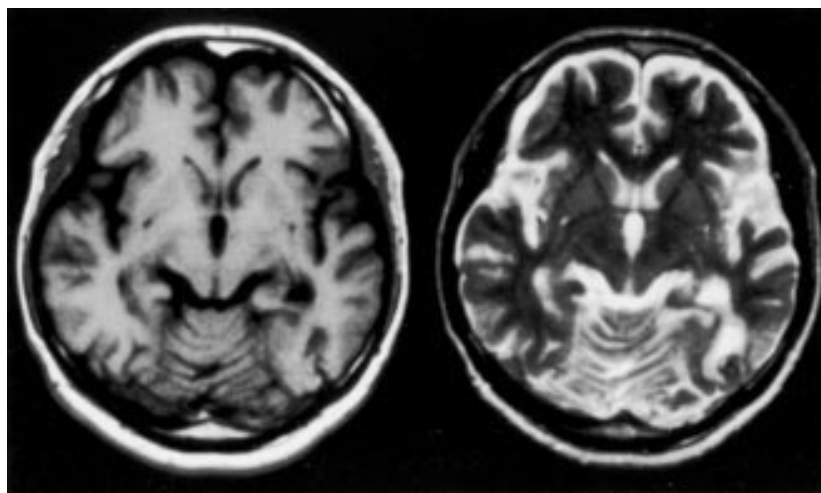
Brain MRI 3 months after admission showed the subcortical lesions in the left temporo-occipital lobe.
